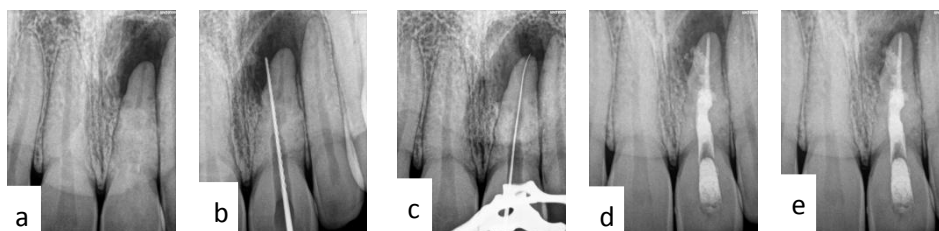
Fig a-e: a-preoperative radiograph b - perforation of root c - working length d - perforation repair e - 6 month follow up
